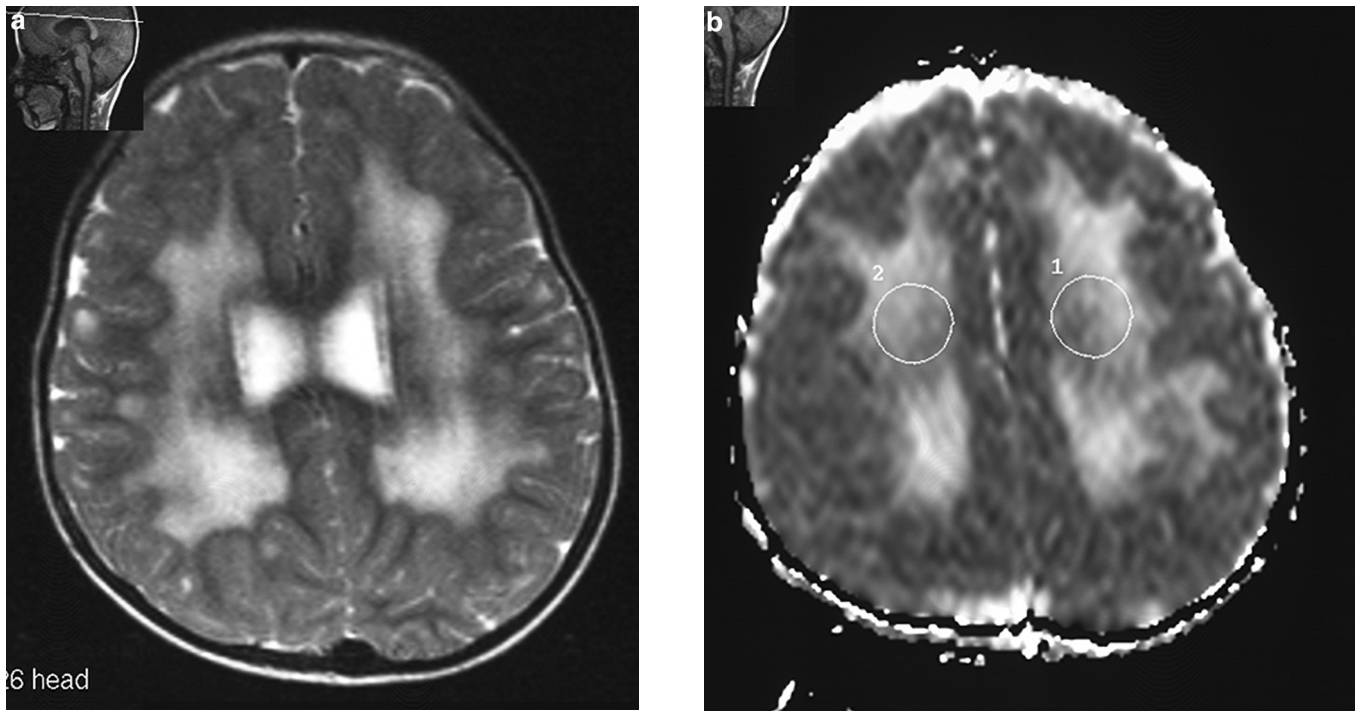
(a) Transverse T2-weighted (repetition time, 4500; echo time, 110 ms) images show high signal intensity in the deep white matter that extends to the arcuate fibers. (b) An apparent diffusion coefficient map reveals high signal intensity and apparent diffusion coefficient values in the deep white matter (1348 and $1308 \times 10^{-6} \text{ mm}^2/\text{s}$).
